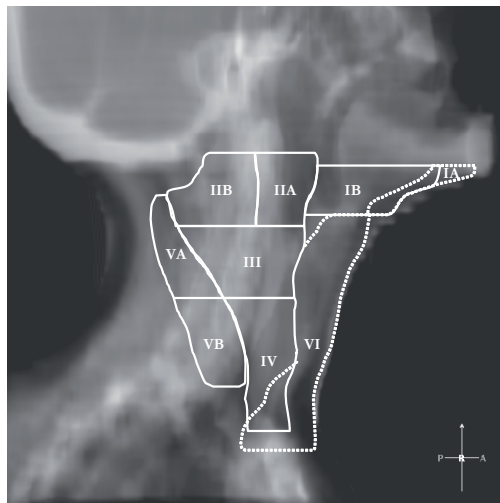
Digital Reconstructed Radiograph levels I-VI.
